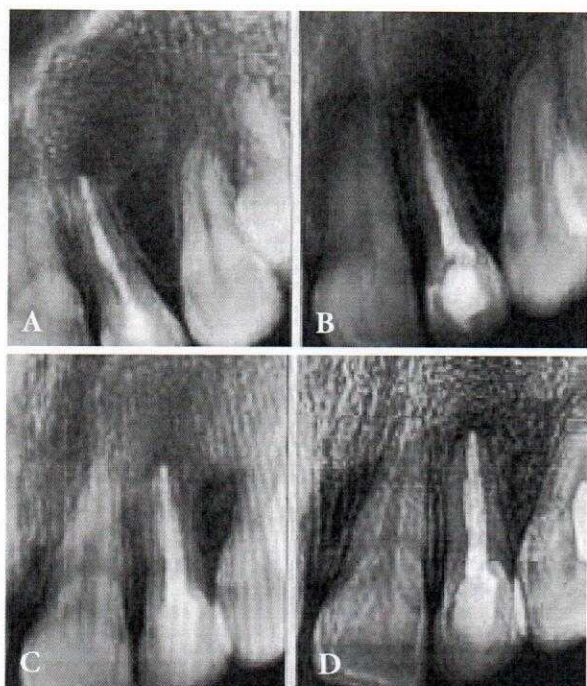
a: Initial periapical radiography; b: Postoperative periapical radiography; c: Follow-up periapical radiography after 12 months; d: Follow-up periapical radiography after 18 months
